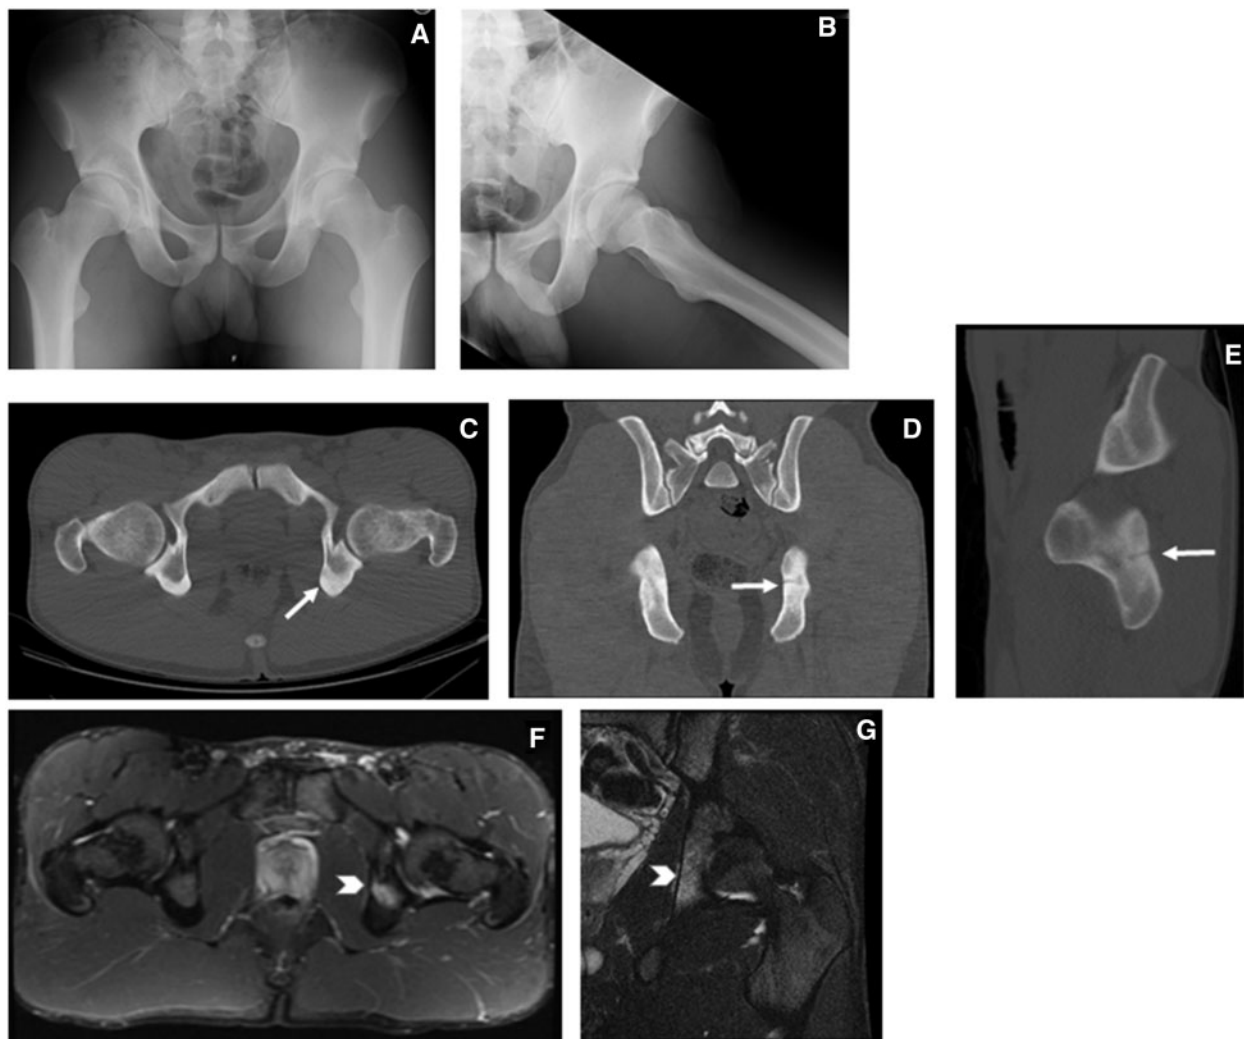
(A) AP pelvis radiograph and (B) left hip Dunn lateral radiograph demonstrating a relatively normal appearing ischium. (C) Axial, (D) coronal and (E) sagittal CT revealing a black line and periosteal thickening (arrow) of the ischium representing the stress fracture non-union. MRI of the left hip and pelvis demonstrate in the (F) axial and (G) coronal plane increased edema (arrow head) in the non-weight bearing portion of the ischium and extending into the posterior column.
